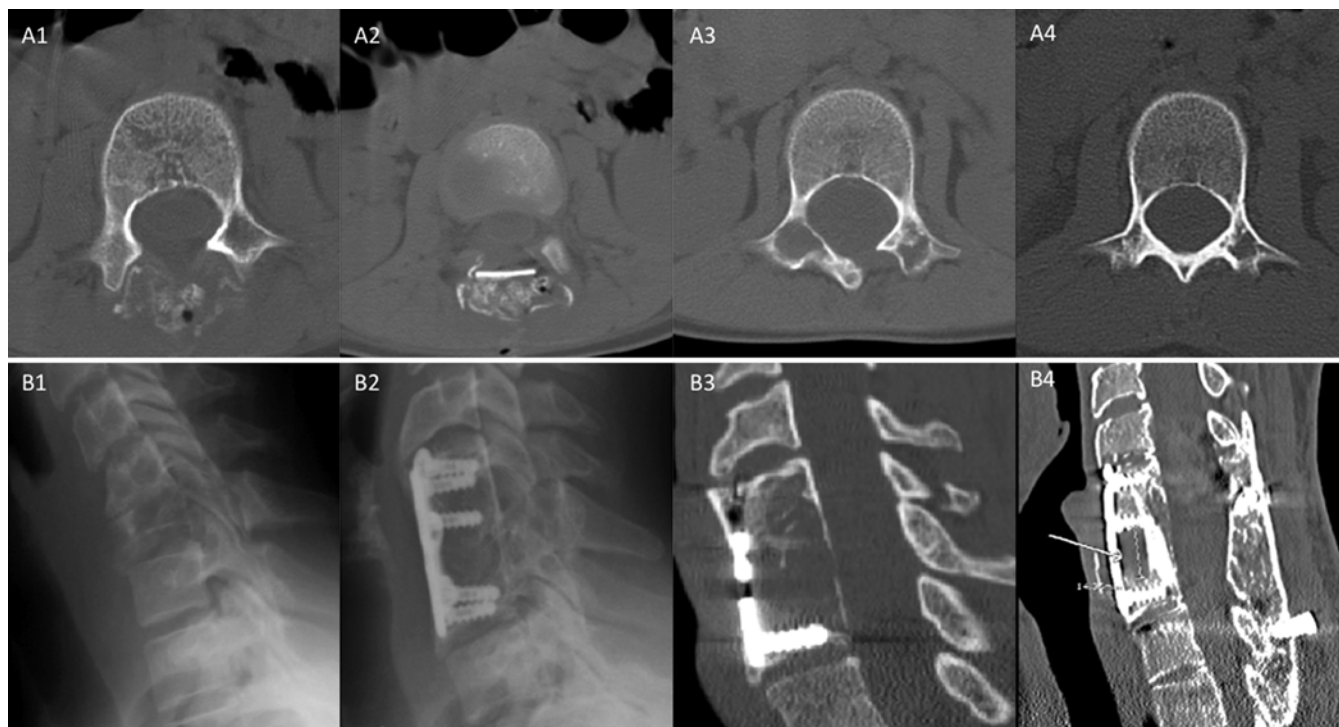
Cases 9 (A) and 14 (B). Imaging obtained in the 2 patients with lesion recurrence. A1 and A2: Axial CT scans obtained 2 days after curettage and bone grafting of an L-2 lesion in an 8-year-old girl involving the spinous process and lamina, extending to the inferior articulating processes. A3: A recurring lesion is shown again involving the lamina as well as the right pedicle of L-2 9 months after the surgery on an axial CT scan. A4: Follow-up axial CT scan obtained approximately 10 years after repeat surgery with recurettage and bone grafting. B1: Lateral radiograph showing an ABC involving the C-6 vertebra in a 15-year-old girl. The lesion had significant paraspinous extension. B2: The lesion was resected and an anterior C5–7 interbody fusion was performed. A small part of the capsule was left behind secondary to significant intraoperative bleeding, as shown on the lateral radiograph. B3: A recurrence at the C-5 and C-6 levels 8 years after surgery is shown on a sagittal CT reconstruction. This recurrence was reexcised through a combined anterior and posterior approach. The existing instrumentation was partially exchanged and supplemented with a posterior C4–T2 fusion. B4: Good fusion and no signs of recurrence are demonstrated 5 years after the second surgery on a sagittal CT scan reconstruction.
